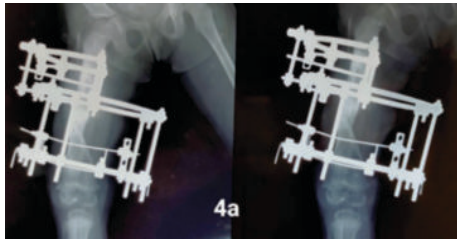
Radiographs after 3 months of follow-up (union can be seen).
